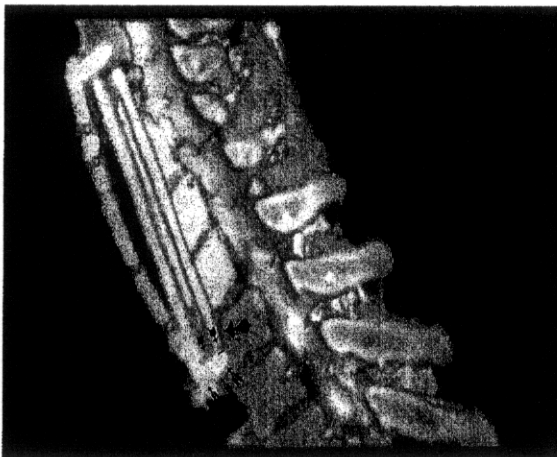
Case 3: A 48-year-old female with severe OPLL originally had a C2-C7 ACF with C2-T1 PWF employing a fixed plate/variable screw plating system with a fibula strut. The graft (large single arrow) and plate extruded anteriorly and inferiorly 1 month postoperatively as demonstrated on this midline sagittal 3D-CT study. Also, note the extrusion of the screw beyond the screw/plate locking mechanism (multiple arrows). Her second surgery required anterior graft replacement from C2 to C7 with application of another fixed plate/variable screw plating system now applied from C2 to T1
